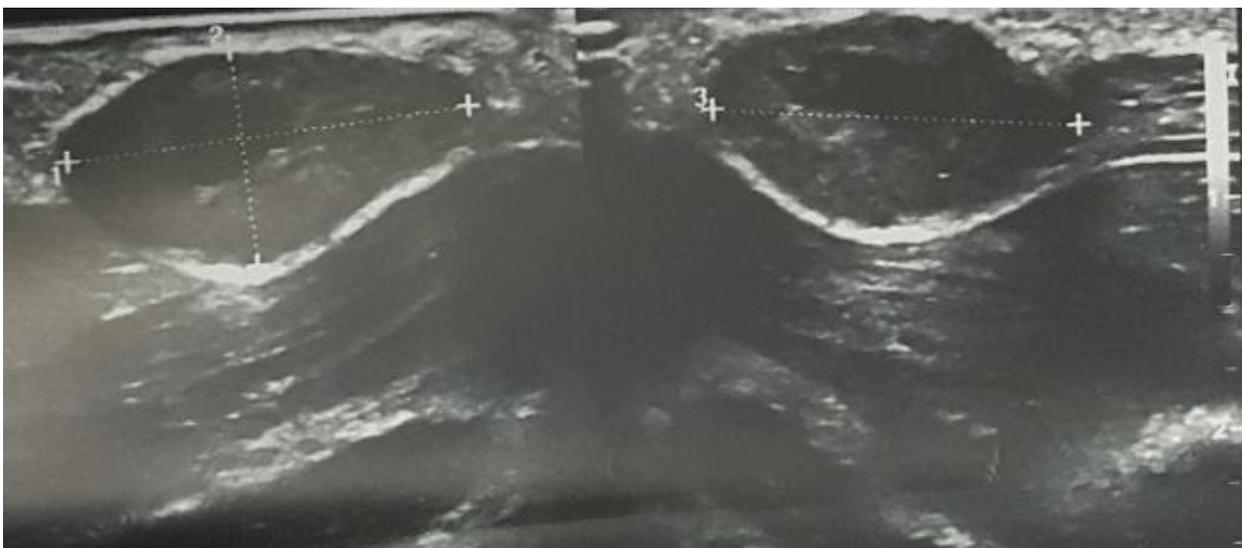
Ultrasonography of the hand showing well defined mass, 1.6cm x 0.9cm x 1.5cm
